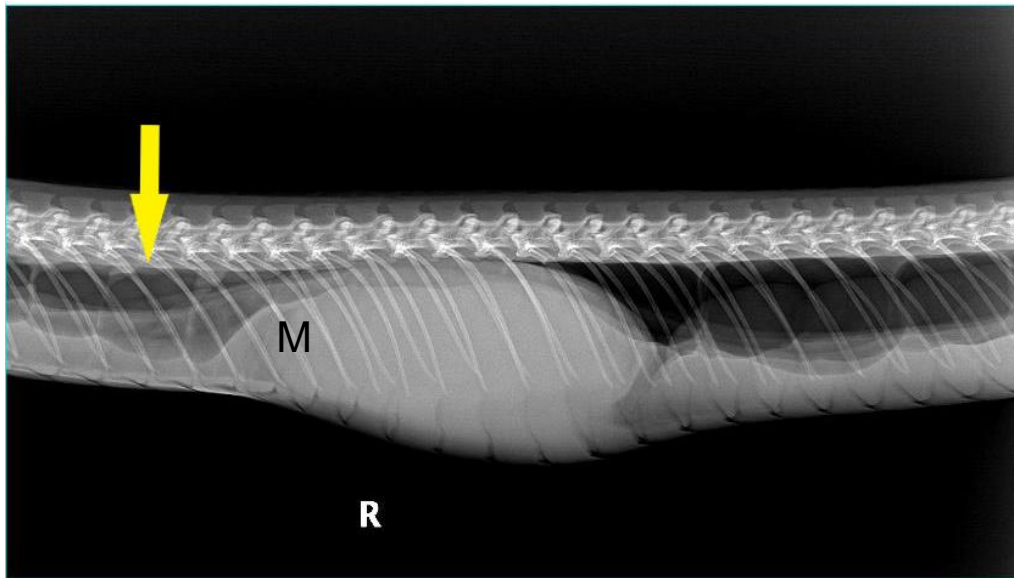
Radiography of soft tissue density mass (M) shows in the coelomic cavity resulting in gastrointestinal obstruction (arrow).
